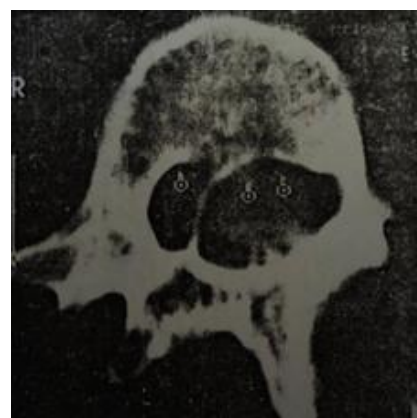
CT of diastematomyelia at L₃ level
